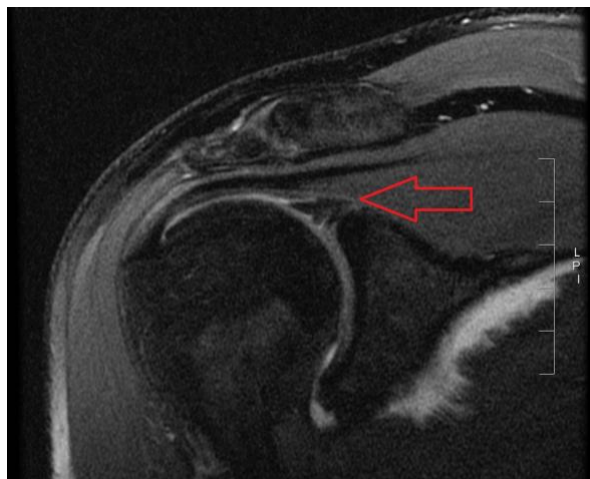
Superior Labral tear from Anterior to Posterior. According to <https://commons.wikimedia.org/wiki/File:MRI.2.SLAP.II.lesion.jpg> [11].
